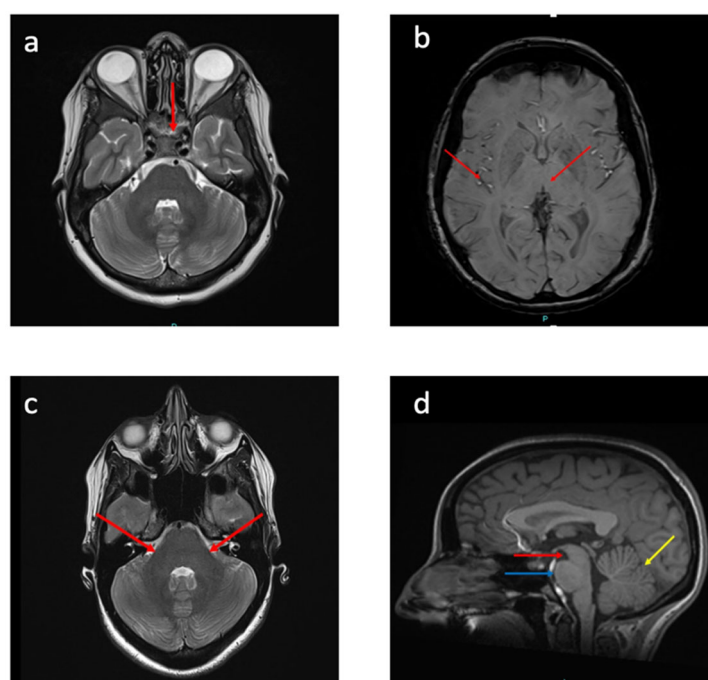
MRI brain scans from a healthy subject highlighting regions typically affected in Multiple System Atrophy (MSA): (a) Axial T2-weighted image of the posterior fossa showing a normally sized pons with no signal abnormalities. (b) Axial T2*-weighted image demonstrating normal, symmetrical signal intensity and volume of the putamen bilaterally. (c) Axial T2-weighted image of the brainstem depicting symmetrical middle cerebellar peduncles with normal signal intensity. (d) Sagittal T1-weighted image showing preserved volume of the midbrain (red arrow) and pons (blue arrow) with a normal midbrain-to-pons ratio, as well as intact cerebellum.
